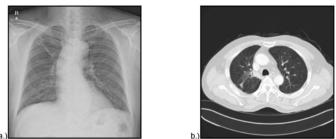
(a) Chest X-ray: after chemotherapy and oncothermia treatment of the right upper lobe atelectasis was not observable. (b) Chest CT: right upper lobe bronchus, bronchial cancer was disappeared [23. Nov. 2010]
